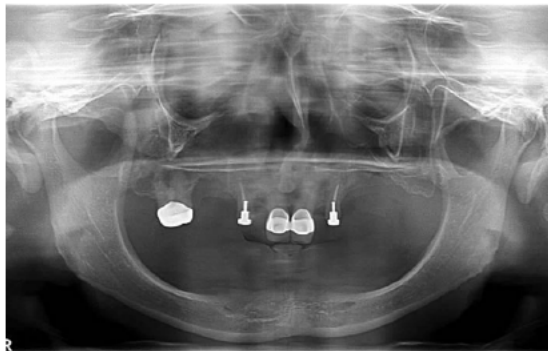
Orthopantomogram of patient.
